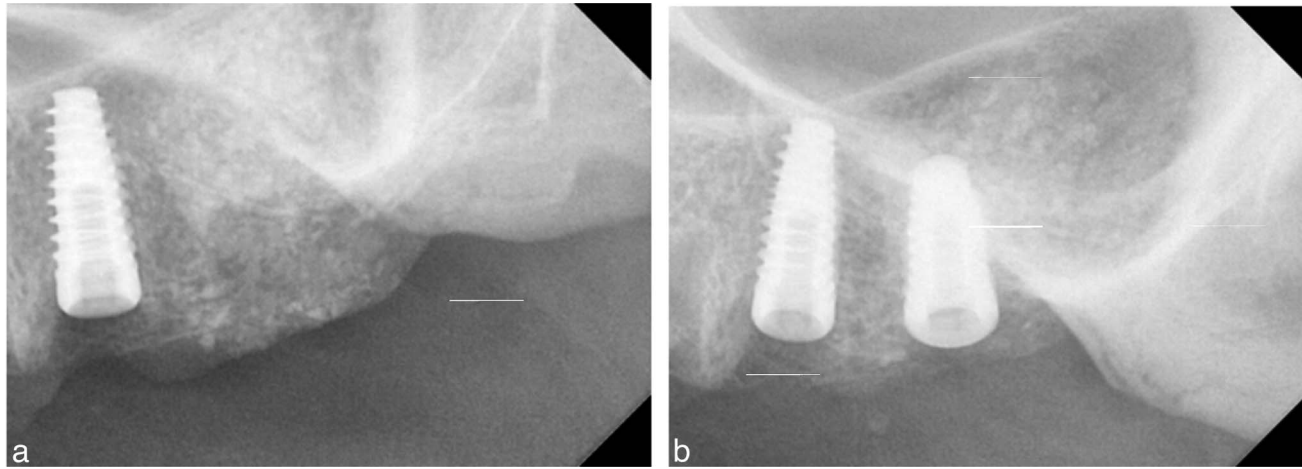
Radiograph following premolar implant placement and sinus augmentation (a) and at implant placement at the molar site 6 months later (b).
